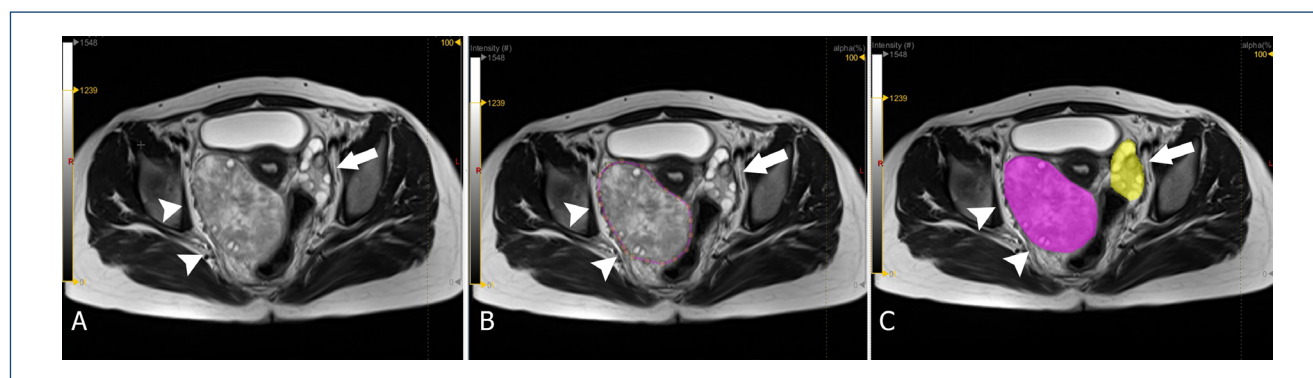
A. 30-year-old women with right-sided surgically proven ovarian torsion. T2-weighted axial magnetic resonance imaging demonstrate enlarged right ovary with peripherally located cysts [arrowheads]. Arrow indicates normal ovary on the left. B. The region of interest included the largest cross-sectional, two-dimensional area [arrowheads] of ovary in axial plane selected on T2-weighted magnetic resonance imaging. C. Both affected [arrowheads] and nonaffected ovaries [affected] manually segmented by the consensus of two radiologists using LIFEx software.
